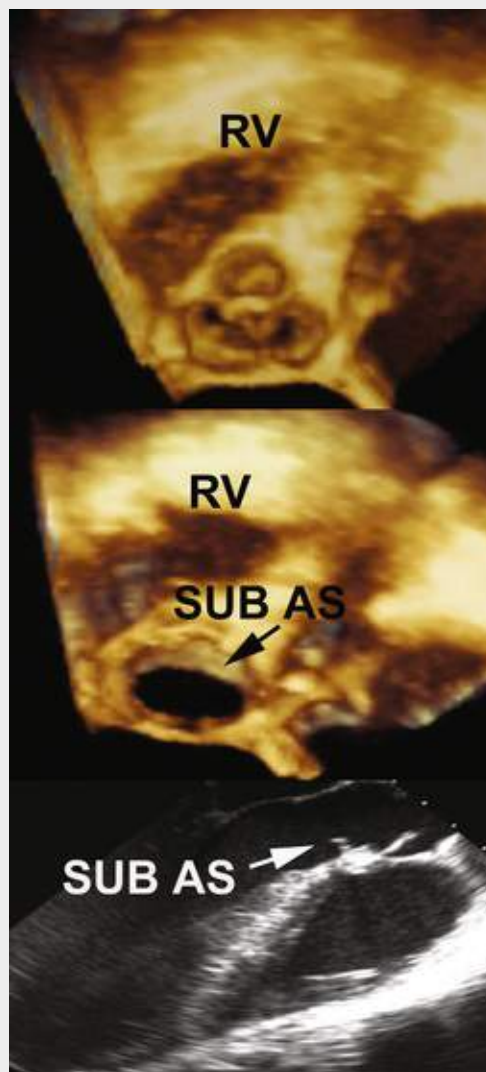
These images demonstrate fibromuscular subaortic stenosis as seen by 3D echocardiography. The upper two panels show the aortic valve as seen by the surgeon; the middle image is just distal to that and shows the crescent-shaped subaortic membrane. The lower image shows the fibromuscular ridge as seen by transesophageal 2D echocardiography. *RV*, right ventricle; *SUB AS*, subaortic stenosis.
